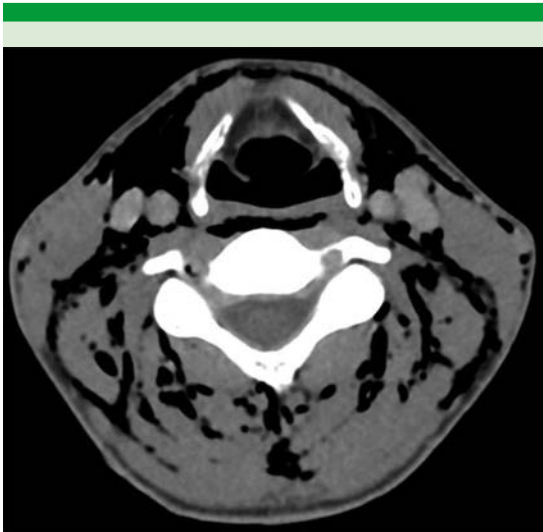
CT shows extent emphysema of the neck.
